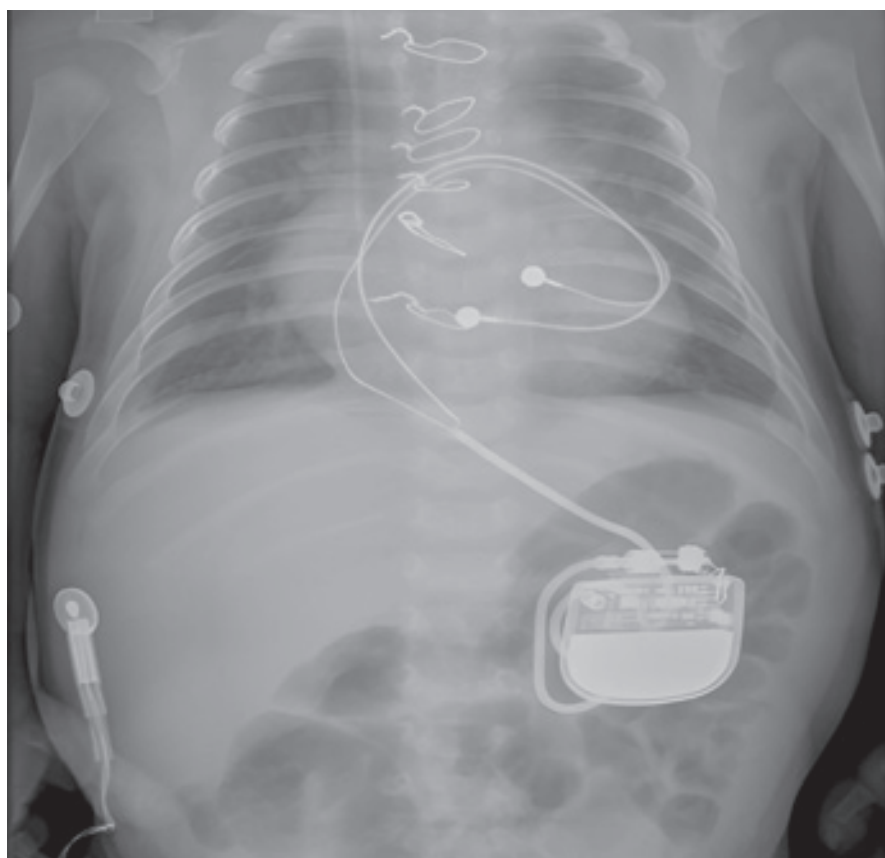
Radiograph of thorax/abdomen in antero-posterior incidence showing an epimyocardial atrioventricular pacemaker implant. Pacemaker is located in the left hypochondrium.
